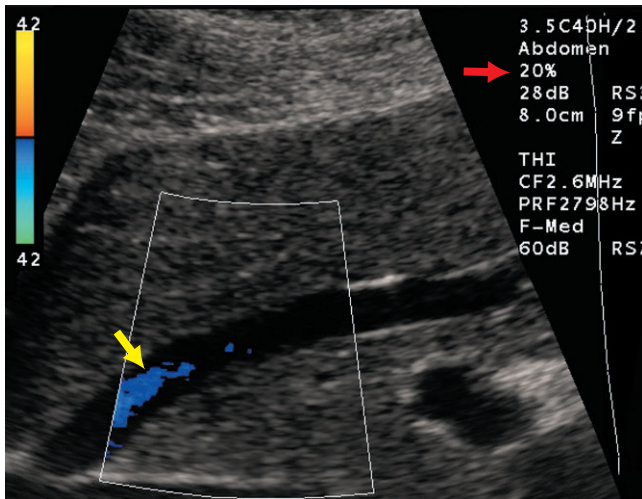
Color Doppler of the hepatic vein. There is a very small amount of color in the vessel (yellow arrow). It is at the left side of the color box where the Doppler angle is lowest. The power is set to 20% (red arrow).
